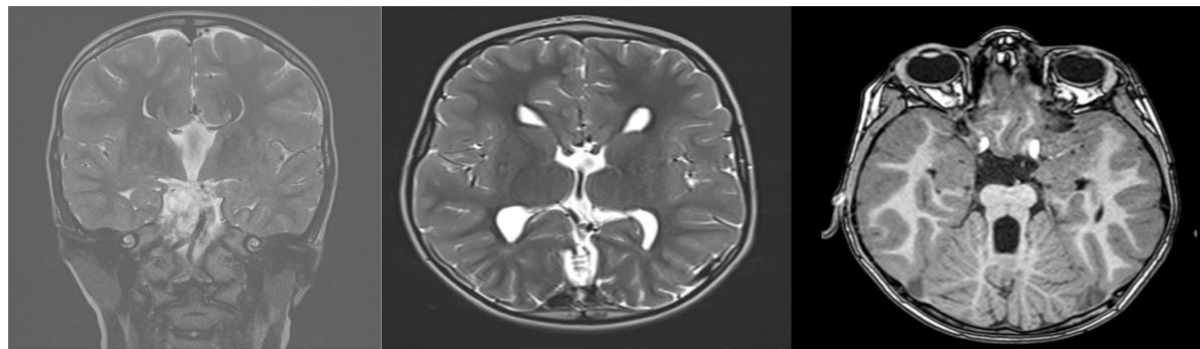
Characteristic brain MRI findings. From left to right: coronal T2-weighted image showing lateral eversion of the frontal horns, producing the bull's-horn appearance; axial T2-weighted image showing parallel and widely separated lateral ventricles, producing the racing-car sign; and axial image at the pontomesencephalic junction showing a deepened interpeduncular fossa with thickened, elongated, horizontally oriented superior cerebellar peduncles, producing the molar tooth sign.
